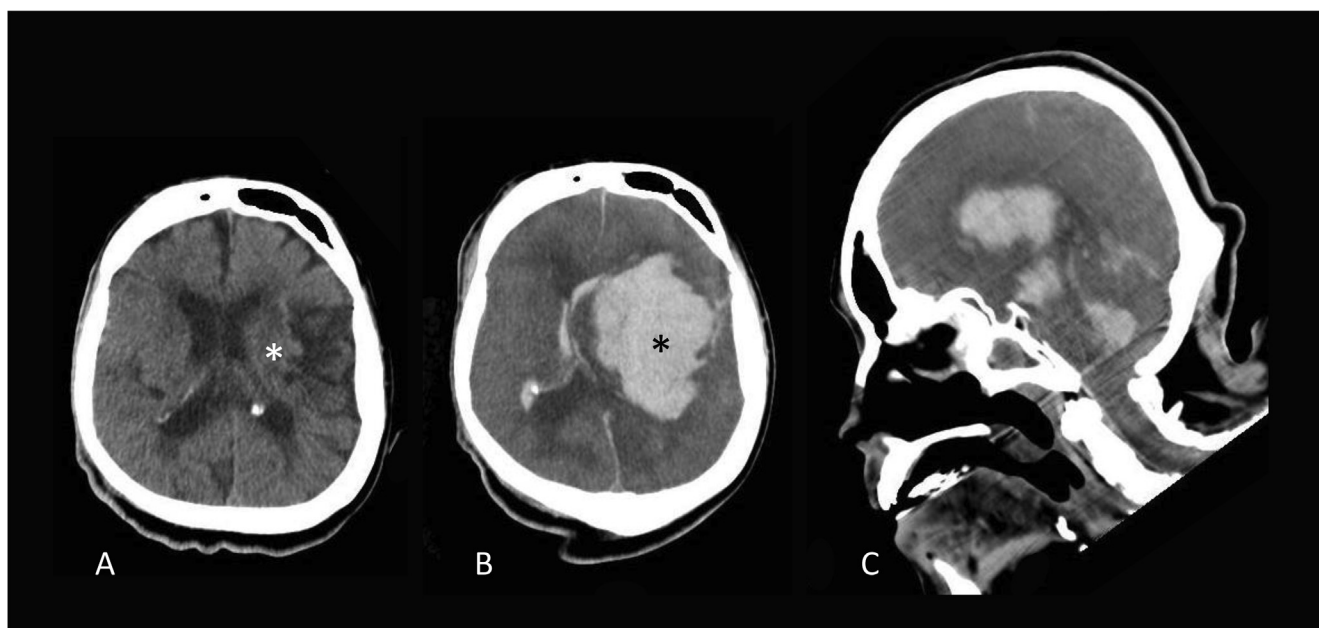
Brain CT performed as a routine evaluation at 65 years and 6 months of age (A), and as an urgent evaluation to investigate the cause of deep coma at 66 years and 8 months of age (B, C). A: Low-density lesions in the left basal ganglia (white asterisk) were found, which were caused by neonatal asphyxia at birth. B: Note the extensive intracranial hematoma in the left basal ganglia (black asterisk) and region corresponding to the asphyxiated basal ganglia lesion (white asterisk in A). C: Bleeding in the basal ganglia ruptured into the lateral ventricles, expanding to the fourth ventricle with global brain edema, resulting in downward herniation of the brainstem.
